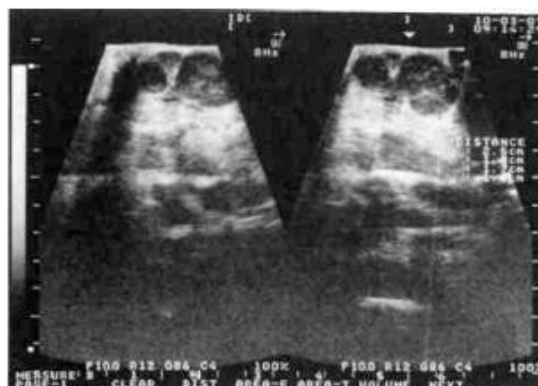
Ultrasound of hyperplastic chronic lymphadenitis of the submandibular region.
